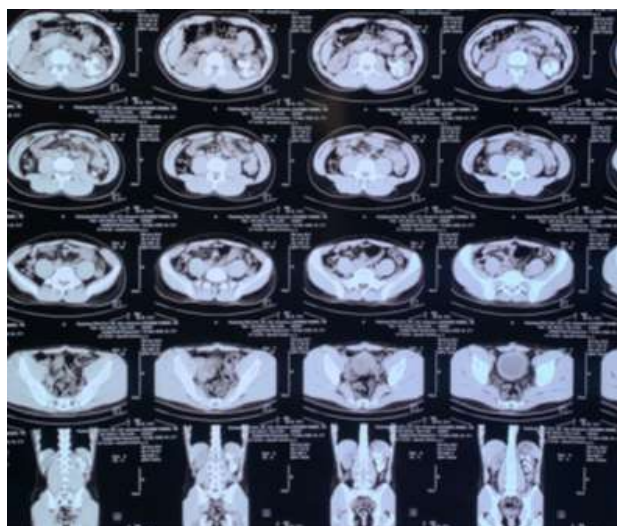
CT SCAN shows renal staghorn stone (4,14 C)
